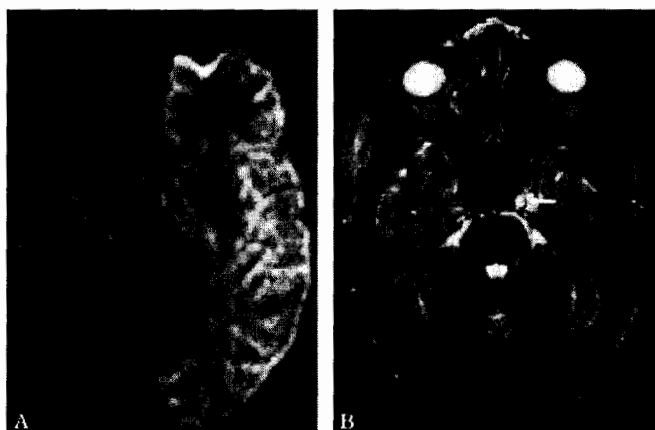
Diffusion-weighted imaging showed high signal intensities in the left cerebral hemisphere (A). T2-weighted imaging showed high signal intensities in the left carotid artery (arrow) (B).
